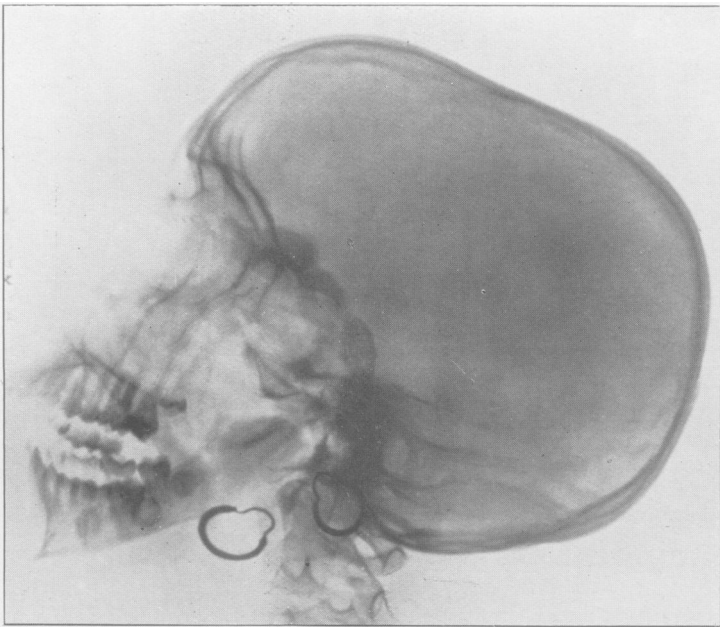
Radiograph of skull three months after operation, showing considerable thickening of the bony arch joining the two sides of the sphenoid. (X-ray report by Major J. C. Coutts.)
